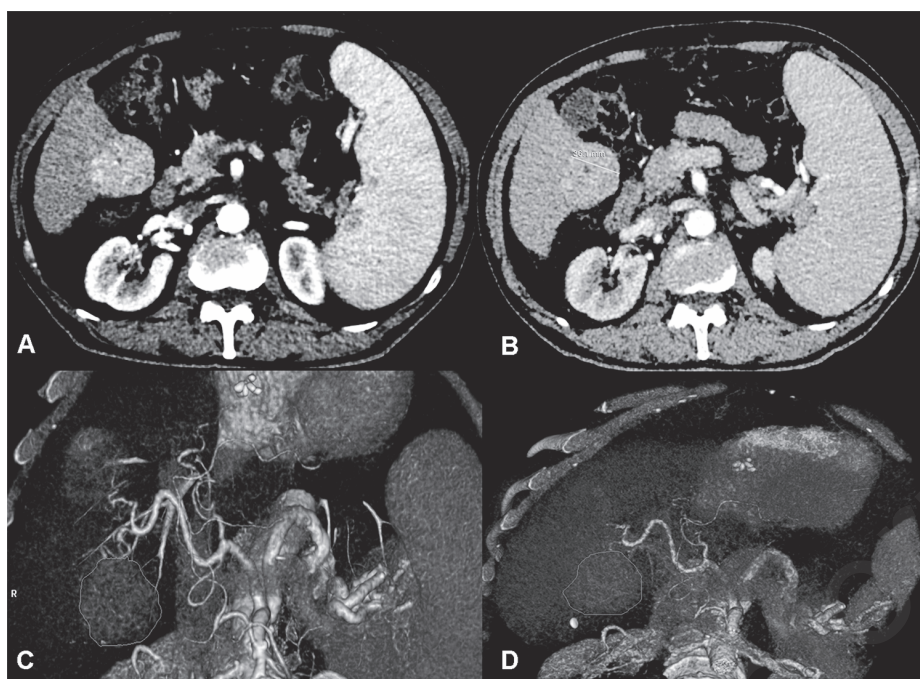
A case of partial response as assessed by MPR CT images on the transverse plane (A: before treatment; B: after treatment) and by 3D analysis software (C: before treatment; D: after treatment).
